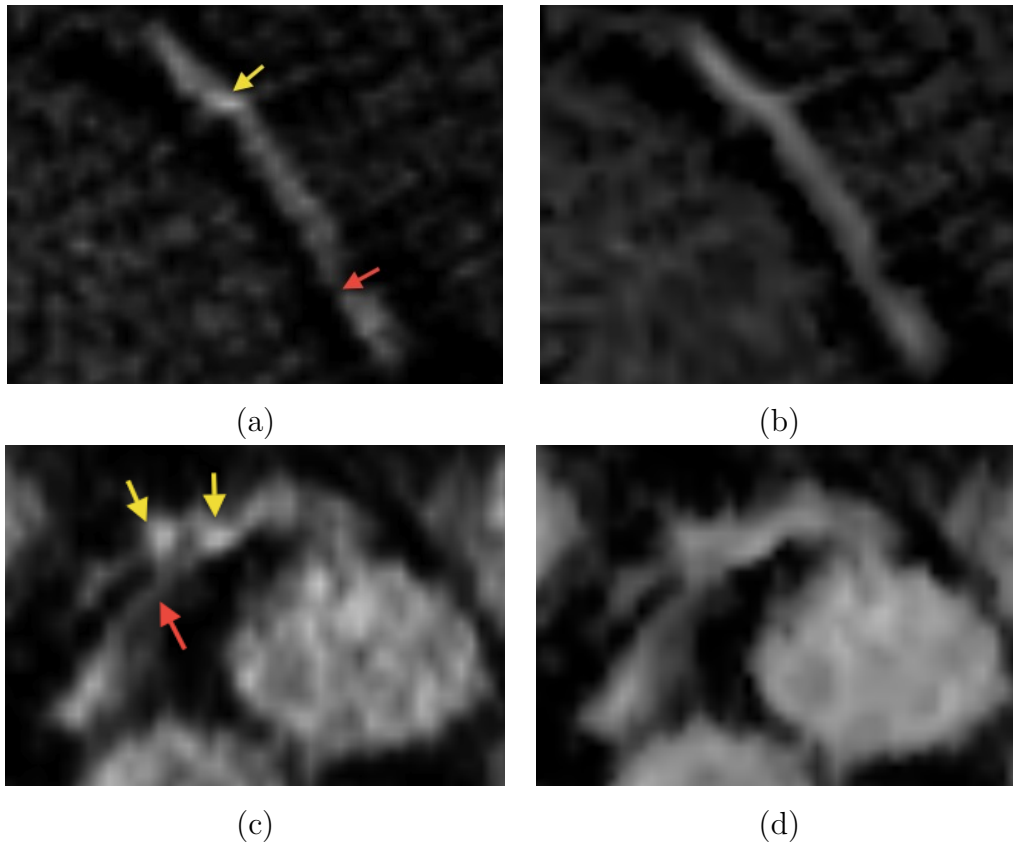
Examples of vessel enhancement diffusion. (a): A segment of the RCA in a CTA image after contrast adjustment; (b): The resulting image of (a) after vessel enhancement diffusion; (c): The left main coronary artery and LAD segments in CTA image after contrast adjustment; (d): The resulting image of (c) after diffusion. The yellow arrows point to calcifications. The red arrows point to narrowing in the arteries.
